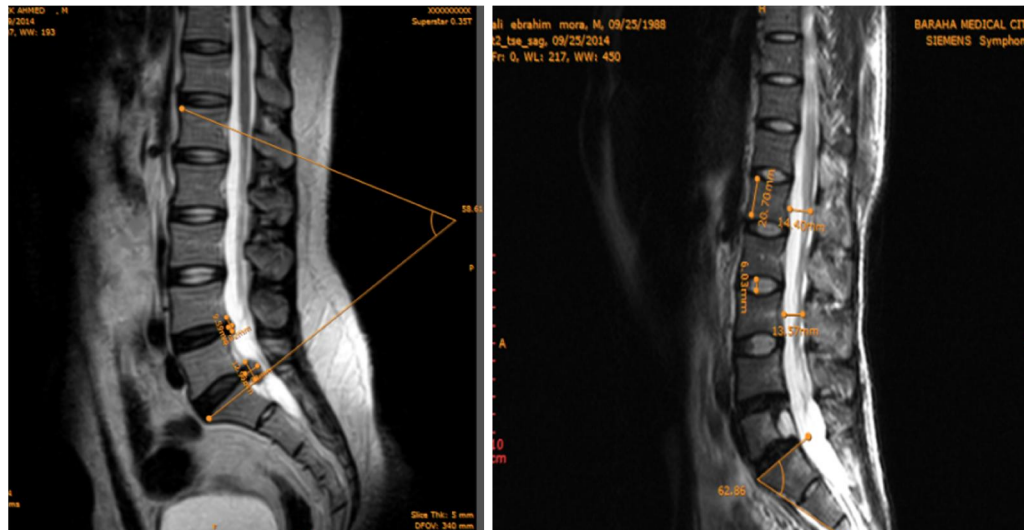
MRI sagittal T2 W images showed measurement of Cobb angle, body diameter, IVD space diameter, LS angle and disc bulge
